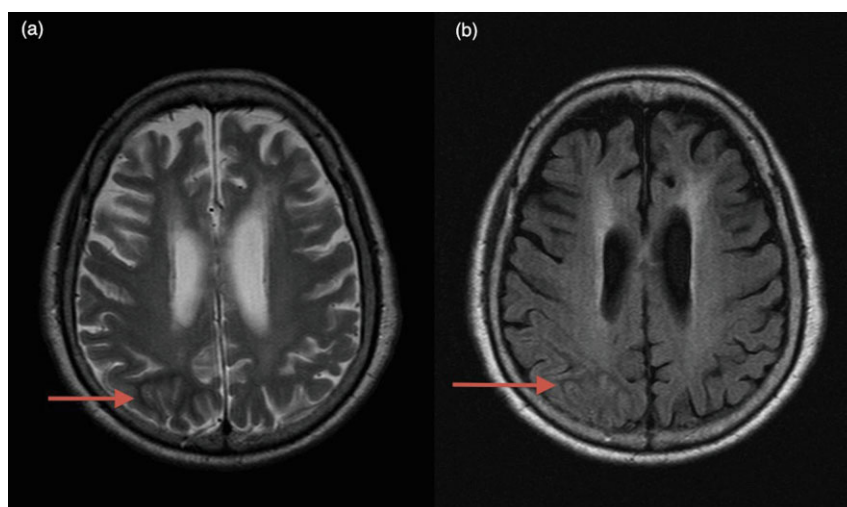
(a) Magnetic resonance imaging (T2-weighted) showed hyperintensities over gray matter of right occipital region, with hypointensities in surrounding subcortical area (arrow). (b) Fluid Attenuation Inverted Recovery showed similar hypointensities over right occipital region (arrow). Obliteration of sulci from focal edema was also present.
